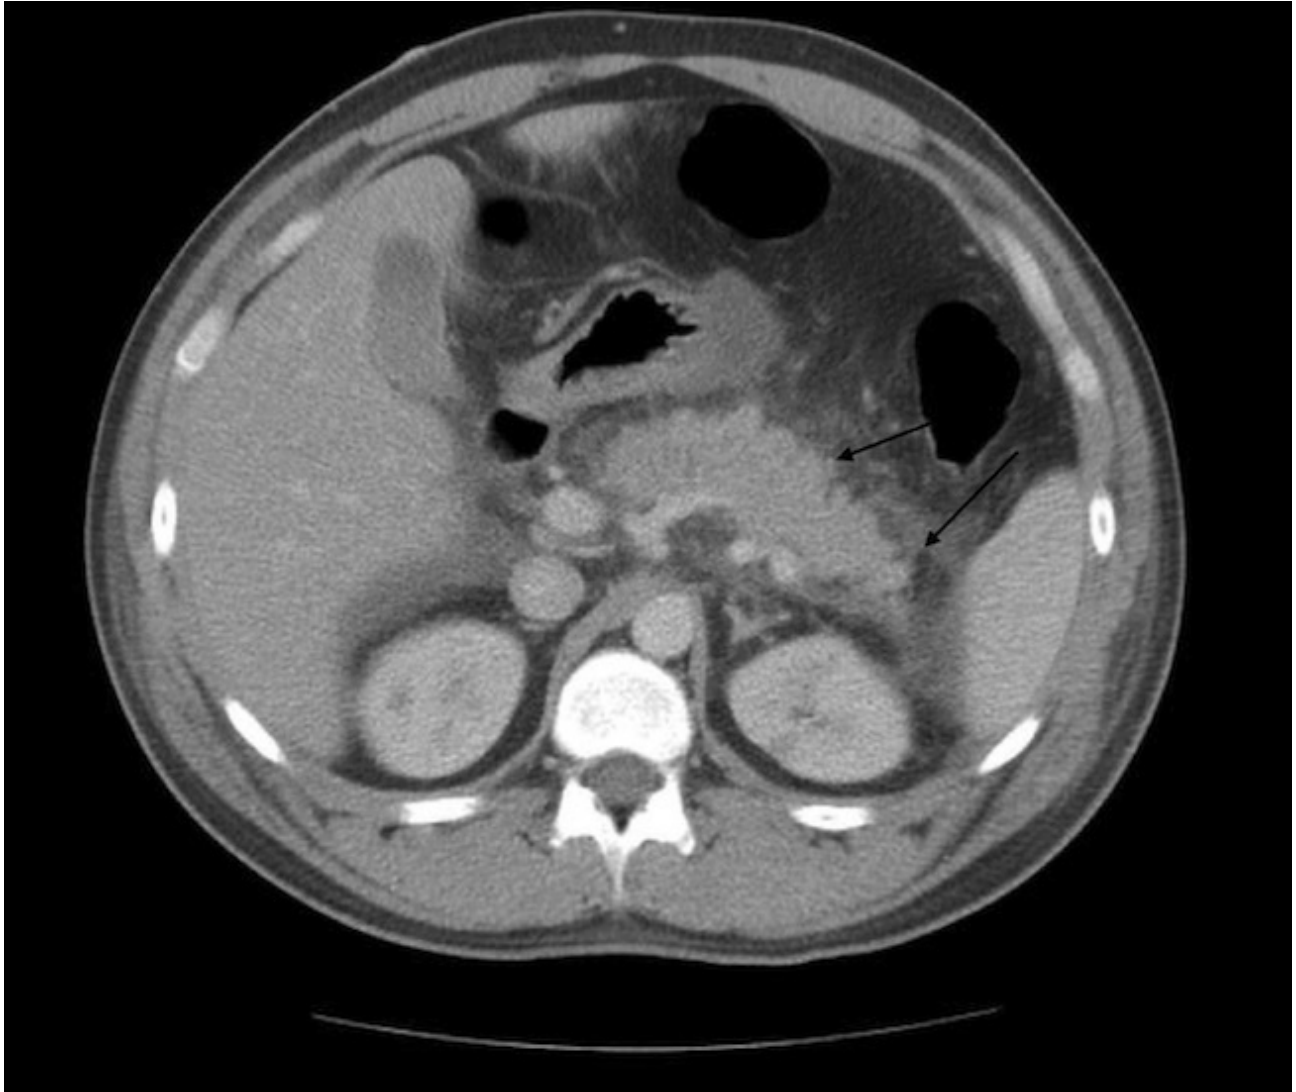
CT scan of the abdomen on day 3 showing moderate to severe peripancreatic inflammatory changes, mainly affecting body and tail of pancreas (arrows).
